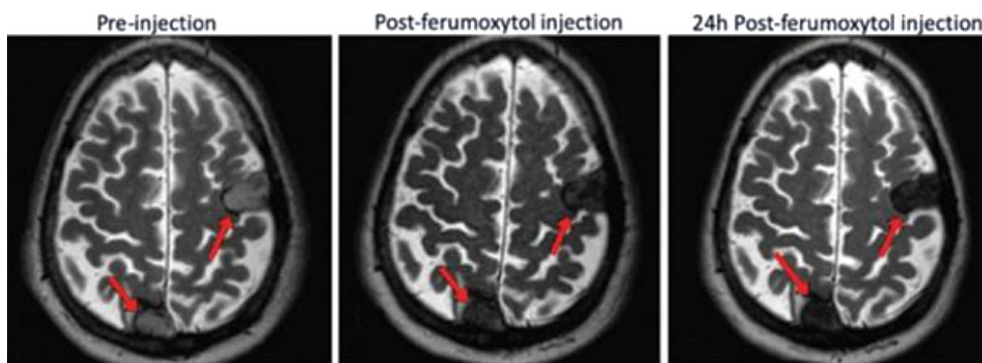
Axial MR images in a 59 year-old male with multiple pancreatic carcinoid tumor dural metastases demonstrates two masses (arrows). Axial T2-weighted MR images show a heterogeneous mildly hyperintense appearance of the dural-based masses (arrows) on non-contrast MRI (left). New hypointensity in both masses (arrows) shown immediately after Ferumoxyl injection (middle). Hypointensity progressively darkens at 24 hours (right).
